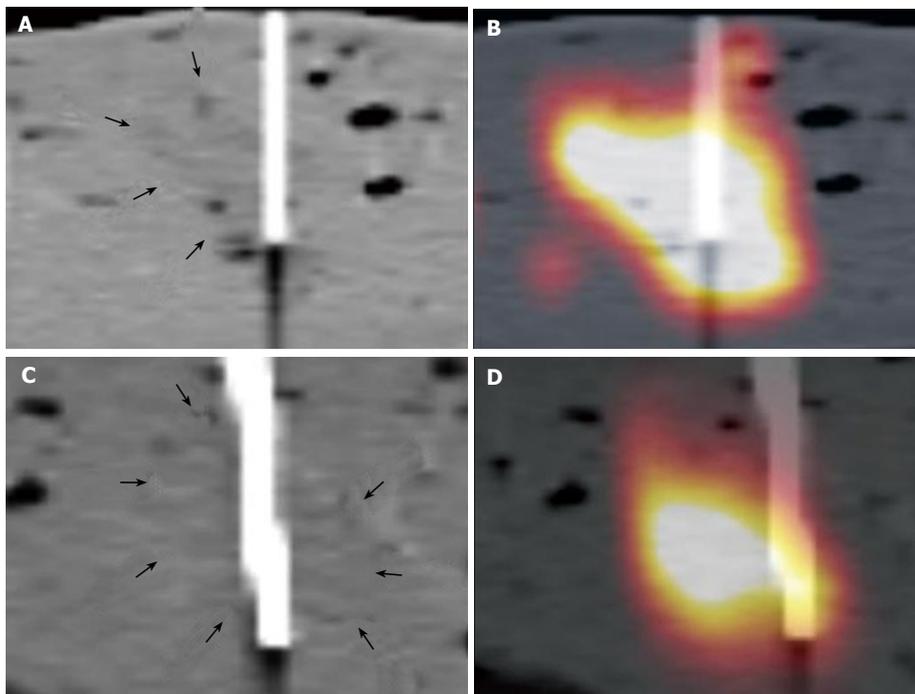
It shows an example of two isodense lesions on CT alone and combined PET/CT with the inserted biopsy needles. The lesions margins are barely seen on CT images alone (fine black arrows, A and C). In comparison, the true extent and localisation of the lesion are well shown on the combined PET/CT images. Based on poor visibility on CT alone, the lesion in the bottom row was nearly missed (D).
